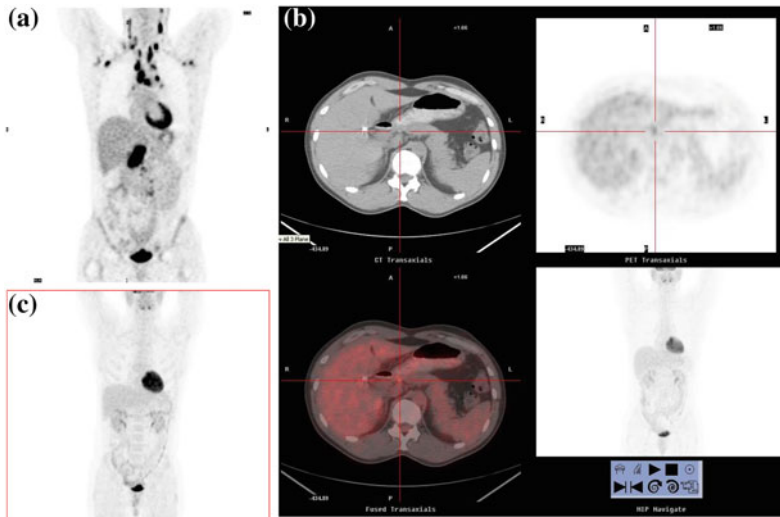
a Baseline staging in a patient with Hodgkin lymphoma, indicating cervical and mediastinal involvement. Conventional staging had revealed mildly enlarged paraortic nodes, which were not demonstrable by PET/CT. Thus, the patient was downstaged from clinical stage IIIA to PET-stage IIA. b PET/CT at the time of relapse in the same patient. PET/CT had been normalized following
